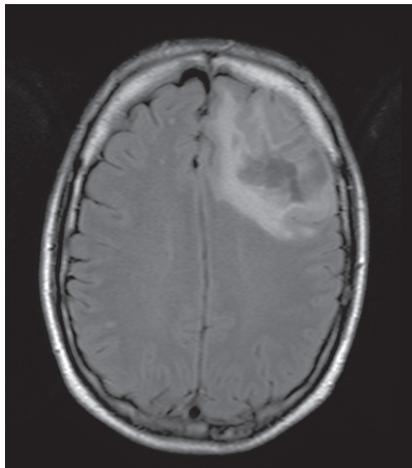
Diffuse glioma. Magnetic resonance imaging (MRI), FLAIR sequence of a diffusely infiltrating glioma located in the left frontal lobe of the brain.
